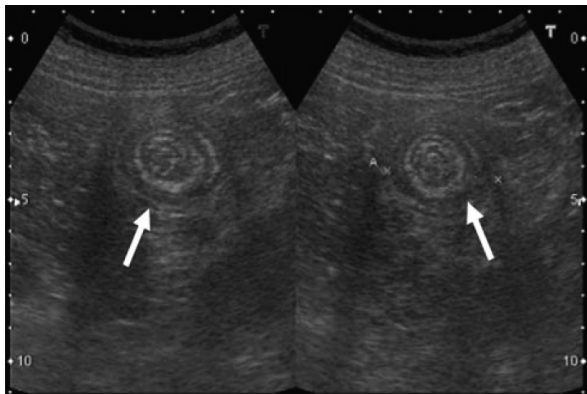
Sonography showing concentric ring sign (arrow).
